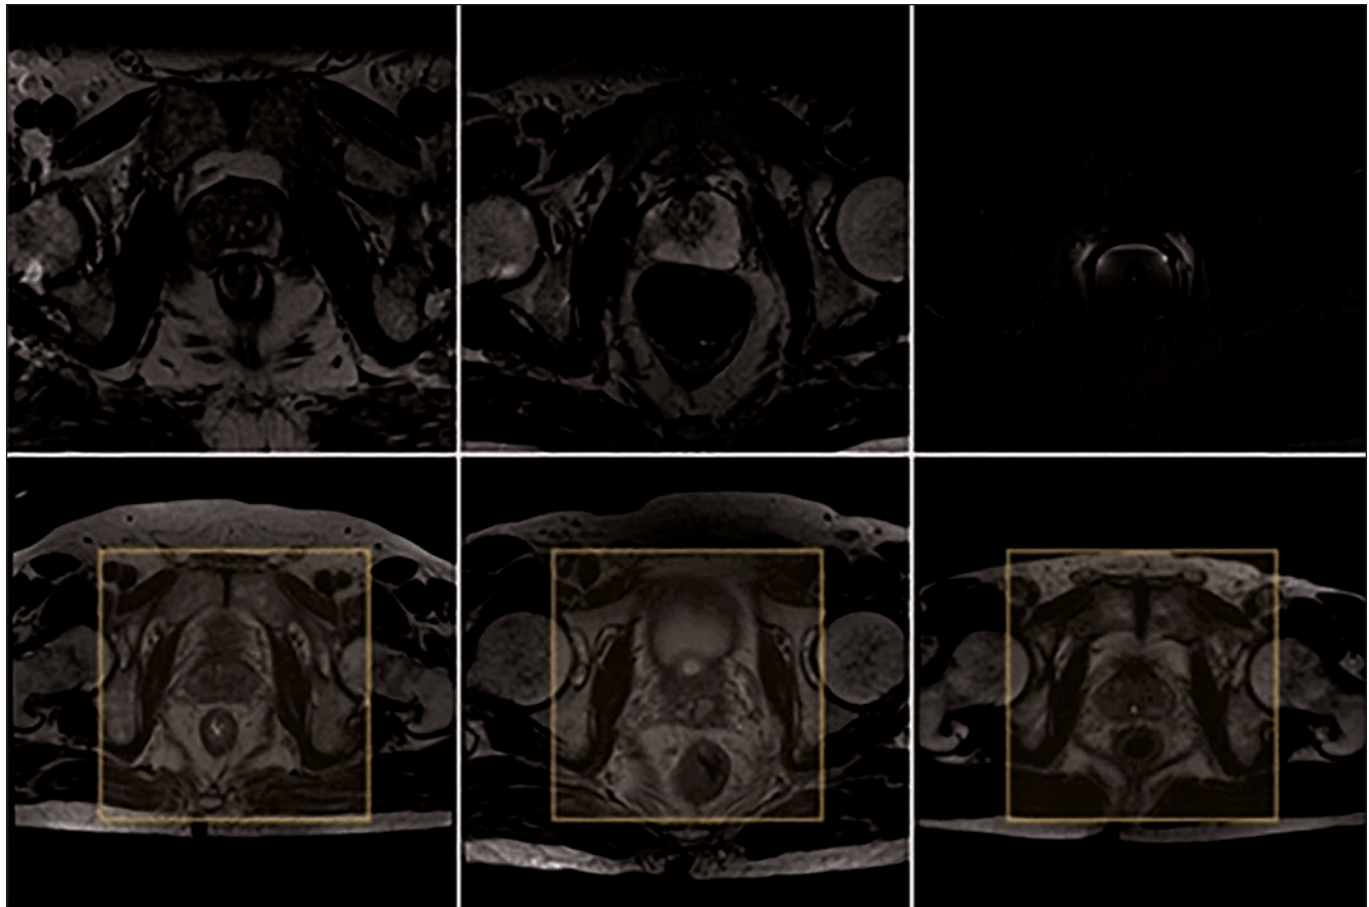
MR images show three slices of data. Yellow box indicates physical area corresponding to Promise12 network (*top*) for comparison with physical area of KUProstate network (*bottom*).
